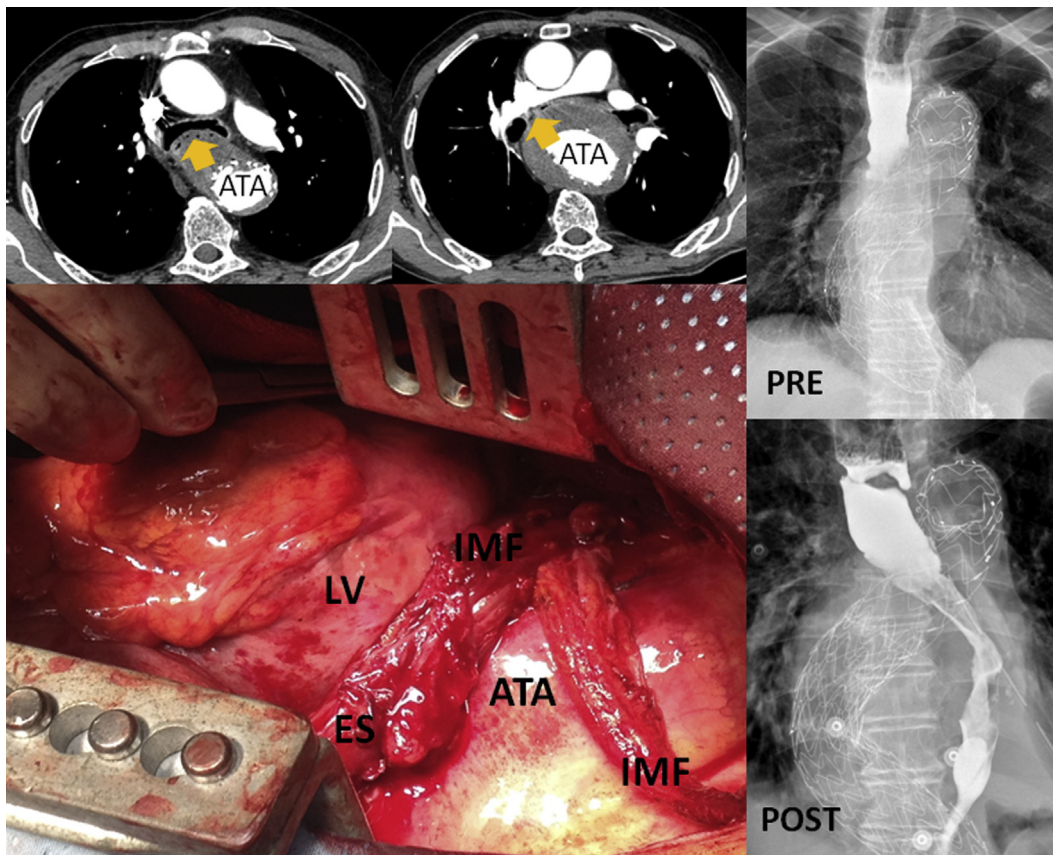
Left and middle upper panels* are preoperative chest computed tomography scans showing a huge aneurysm of the thoracic aorta including endovascular graft stents compressing the middle third of the esophagus (*arrows*), and the *right upper panel* is a preoperative (*PRE*) esophagogram showing esophageal obstruction and abrupt interruption of the contrast medium above the aneurysm level. The *left lower panel* shows esophageal wall reinforcement by a pedicled intercostal muscle flap sutured over the necrotic tract of the esophagus. The *right lower panel* shows a postoperative (*POST*) barium esophagogram with restored continuity of the esophageal lumen and no extraesophageal leakage of the contrast medium. *ATA*, Aneurysm of the thoracic aorta; *LV*, left ventricle; *IMF*, intercostal muscle flap; *ES*, esophagus.
